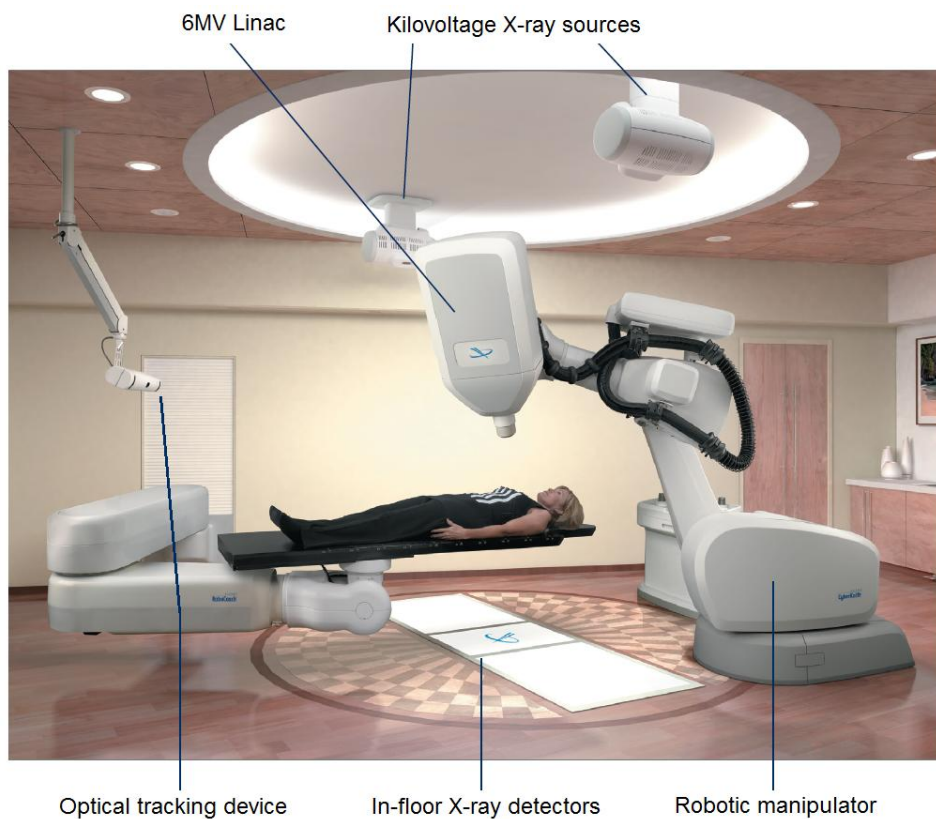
The CyberKnife system, composed by a robotic arm carrying the linear accelerator, two ceiling-mounted X-ray sources, two flat-panel detectors on the room’s floor and an optical tracking device. The patient wears the Synchrony vest, equipped with three infrared markers.
